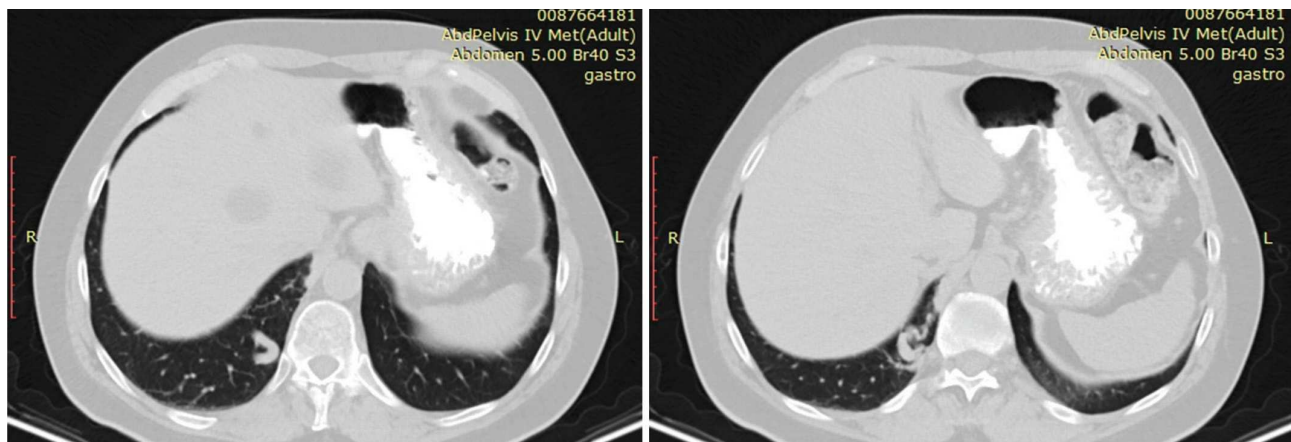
Chest computed tomography revealed a serpiginous mass connected with blood vessels in the right lower lobe.
